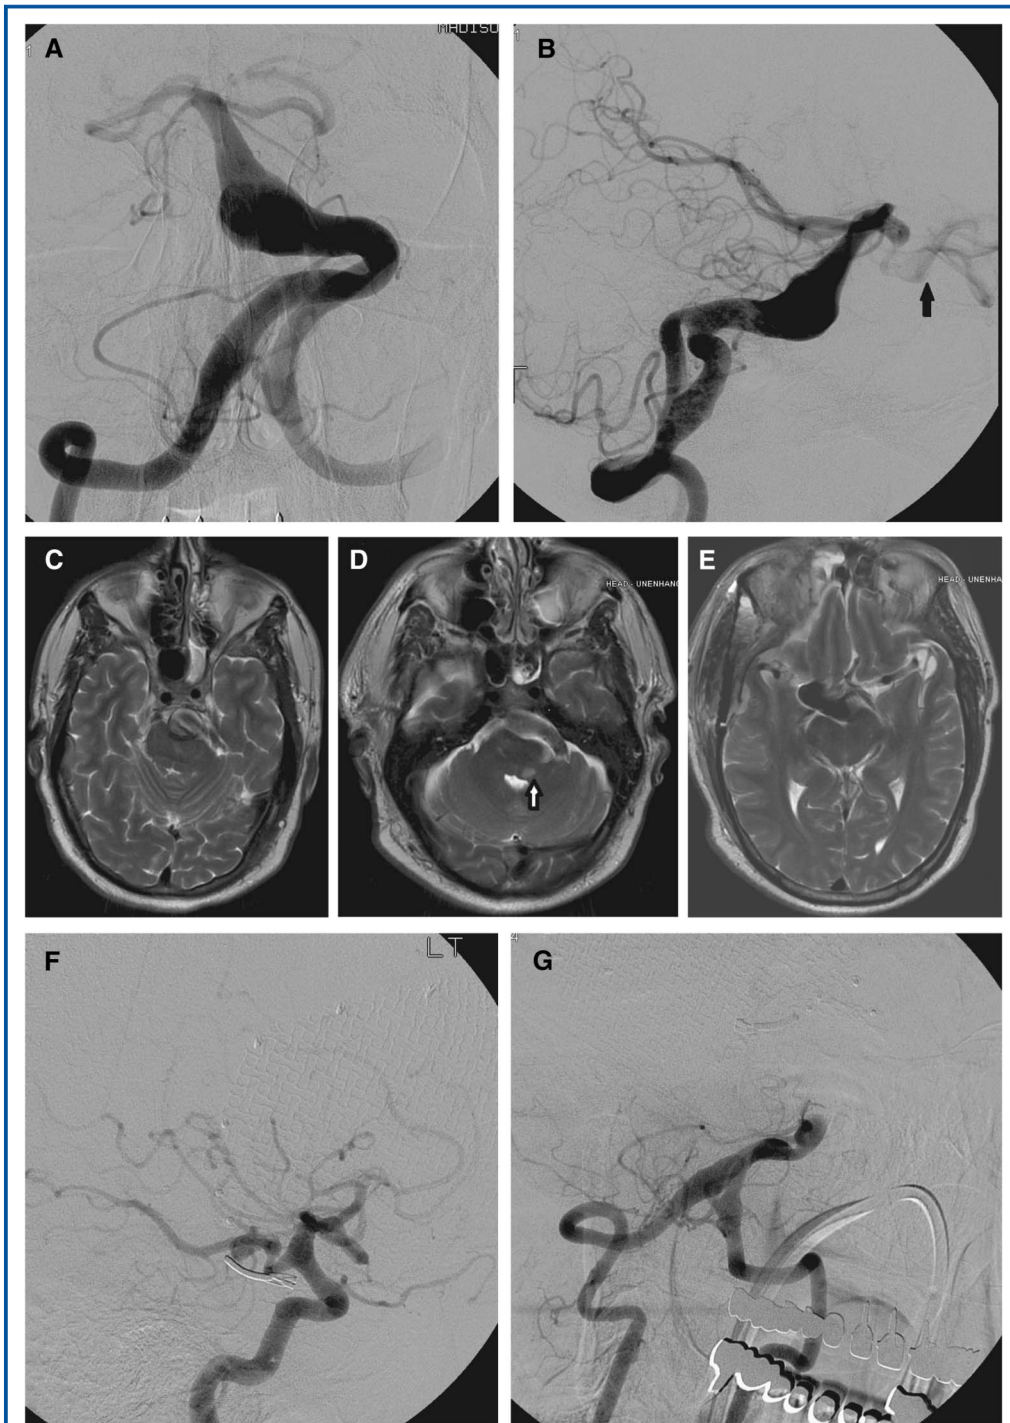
Preoperative anteroposterior (A) and lateral (B) vertebral arteriographic images demonstrate a fusiform basilar aneurysm in a patient presenting with brainstem ischemia and subsequent subarachnoid hemorrhage. The black arrow demonstrates filling of the internal carotid artery (ICA) through a competent posterior communicating artery. Preoperative (C) and postoperative (D, E) axial magnetic resonance images demonstrate the large aneurysm compressing the brainstem and limited ischemic injury to the pons (arrow). F, delayed postoperative arteriographic image of the ICA (obtained 1 year after surgery) reveals excellent filling of the upper basilar artery through the posterior communicating artery. G, corresponding vertebral arteriographic image shows retrograde thrombosis of the basilar artery without evidence of aneurysm filling.
